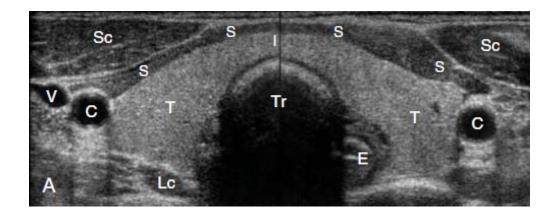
Normal thyroid appearance on ultrasound, Sc-Sternocleidomastoid muscle, S-Strap muscles, V-Internal jugular vein, C-Common carotid artery, T-Thyroid lobes, ,Lc-Longus coli muscles, E-Esophagus, Tr-Trachea(1).
